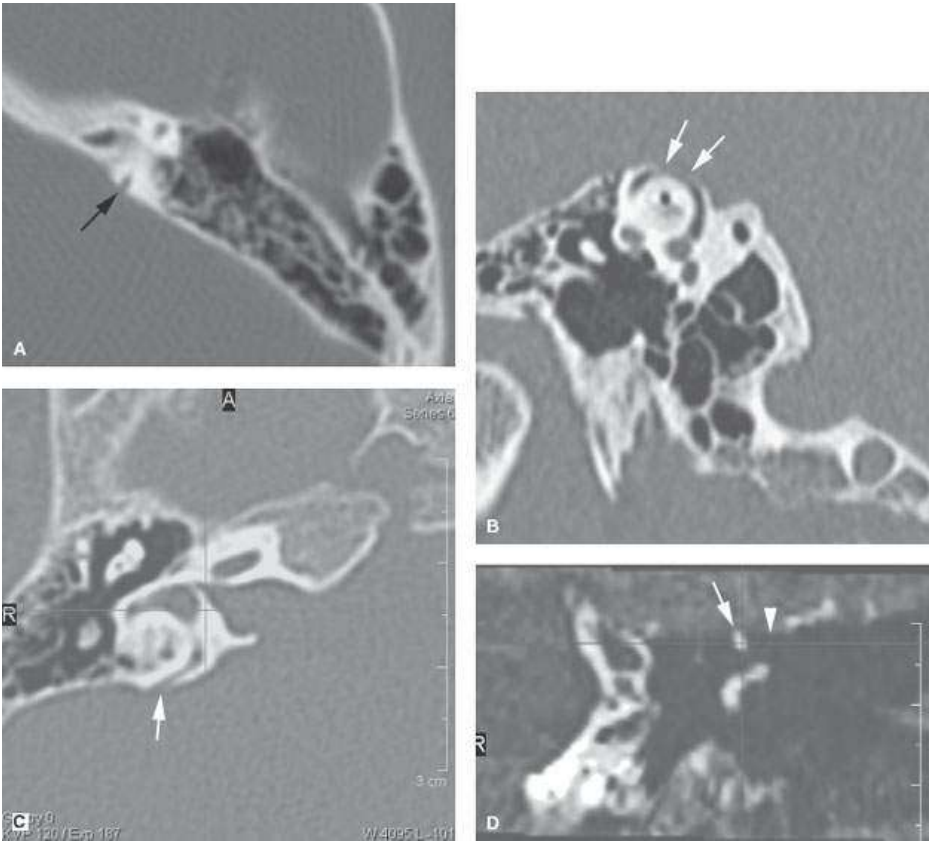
Images in four patients with dehiscent semicircular canals (*arrows*) that might be the cause of inner ear dysfunction. A: Axial section of a dehiscent superior semicircular canal (SSCC). B: Oblique reformatted computed tomography (CT) image showing dehiscence of the SSCC. C: CT of a dehiscent posterior semicircular canal. D: Magnetic resonance imaging in the coronal plane. The arrowhead indicates the roof of the temporal bone.
